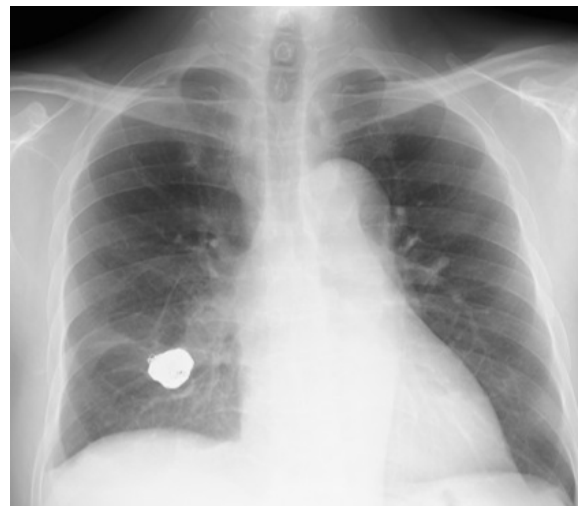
Chest radiography 6 months after intrasaccular coil embolization shows no coil compaction and migration.
